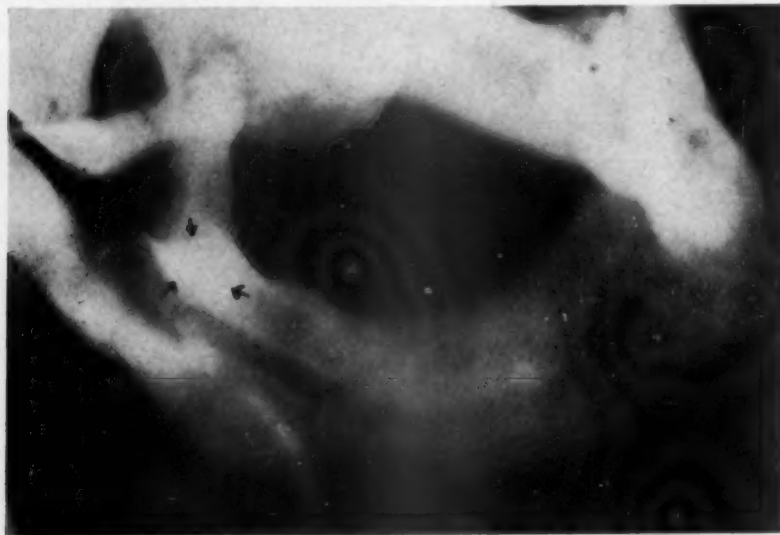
Lateral x-ray showing a new sequestrum on the outer side of the mandible below the mandibular notch.
